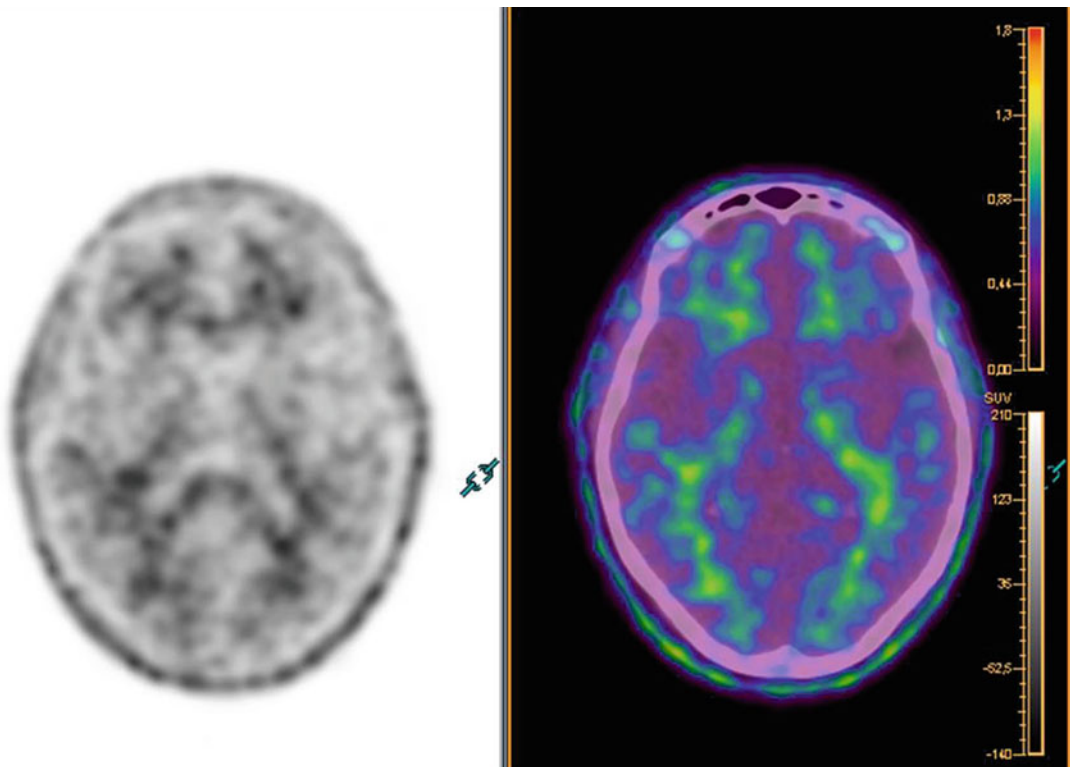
A representative negative ^{18}F -florbetapir PET (*left*) and PET–CT (*right*) in patient with frontotemporal lobar degeneration
